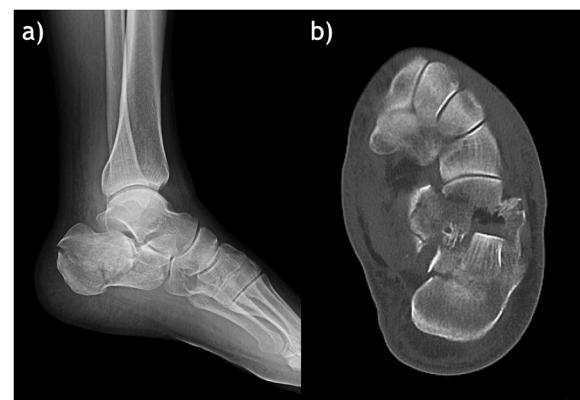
The patient before treatment, (a) lateral X-ray, CT scan (b).
